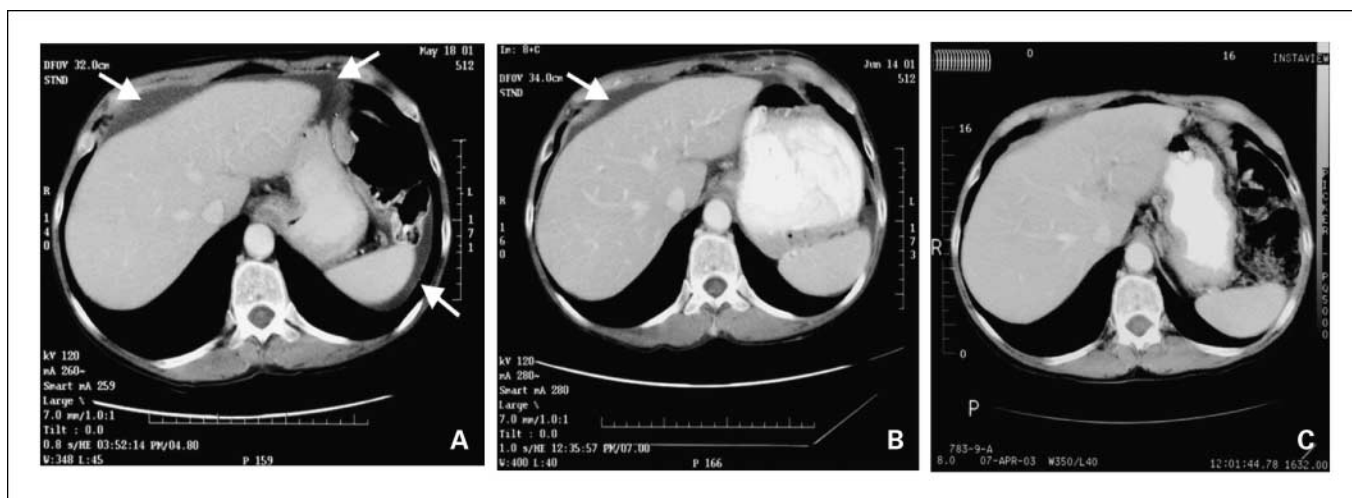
Abdominal computed tomography scan of a 53-year-old female with peritoneal mesothelioma before treatment (A), 4 wks after initiation of SS1P therapy (B), and 23 mo after initiation of SS1P therapy (C). Patient had complete resolution of ascites and died $>$ 5 y after SS1P treatment with no intervening therapy for her mesothelioma.
